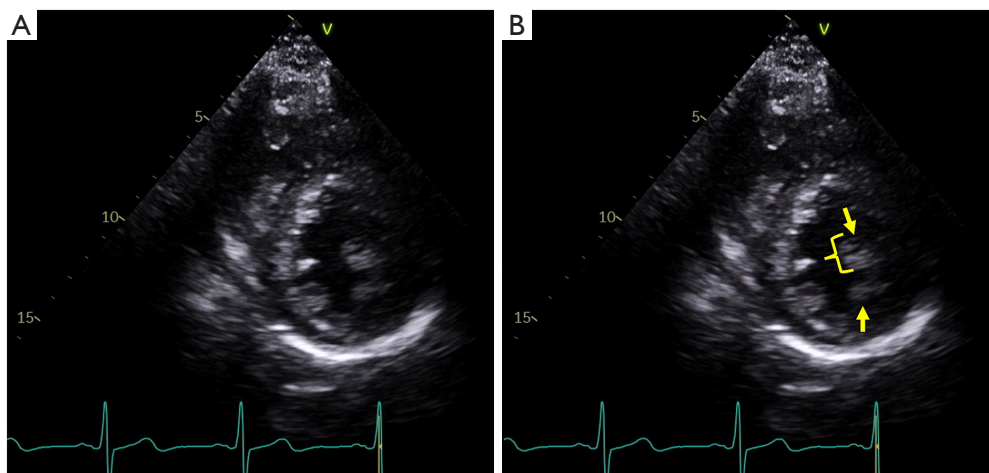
Papillary muscle abnormalities in hypertrophic cardiomyopathy. (A) An end-diastolic parasternal short-axis view; (B) the arrows point to a bifid anterolateral papillary muscle, with the bracket highlighting a hypertrophied anterior head measuring 13 mm in thickness.
